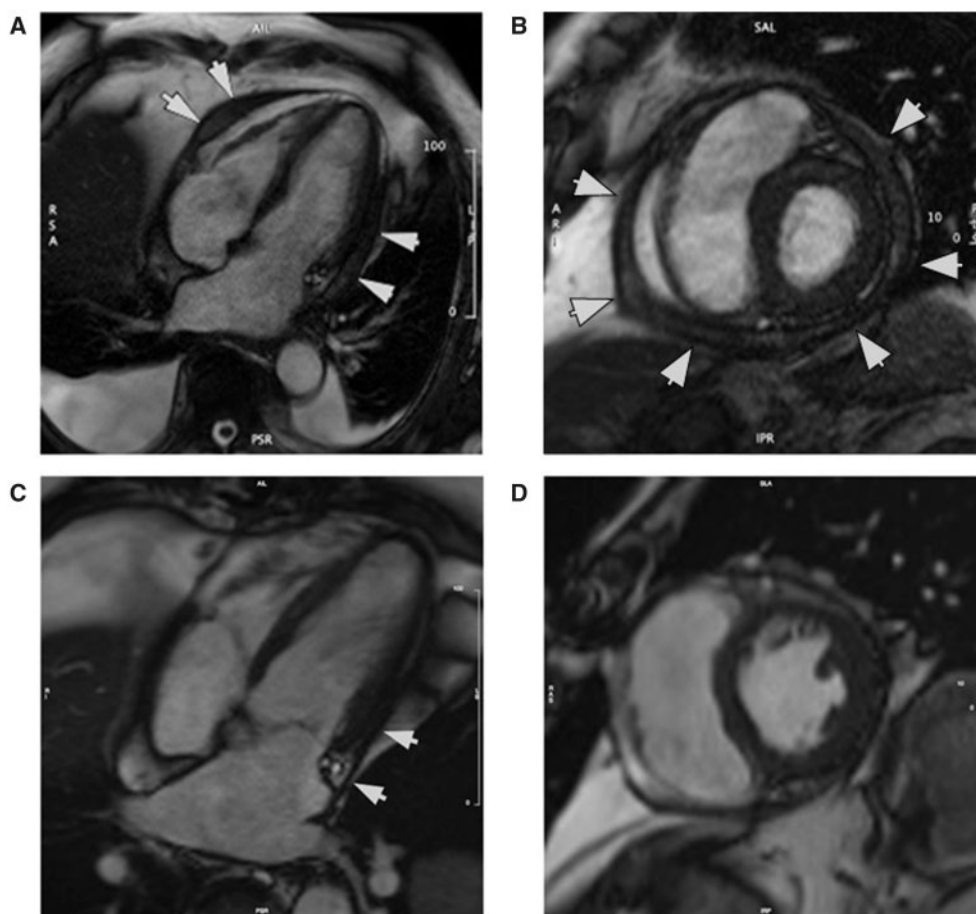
Cardiovascular magnetic resonance imaging. (A and B) Pre-operative cardiovascular magnetic resonance imaging—four-chamber (A) and mid-ventricular short-axis (B) views showing grossly thickened pericardium (arrowed) and bi-atrial dilatation. (C and D) Cardiovascular magnetic resonance acquired at 18-month post-surgery. Four-chamber (C) and short-axis (D) views highlighting reduction in pericardial thickening following pericardectomy and immunomodulation with ruxolitinib. Mild residual pericardial thickening can be noted remaining surrounding left ventricle lateral wall (arrowed; [Supplementary material online, Videos S1–S5](#)).
